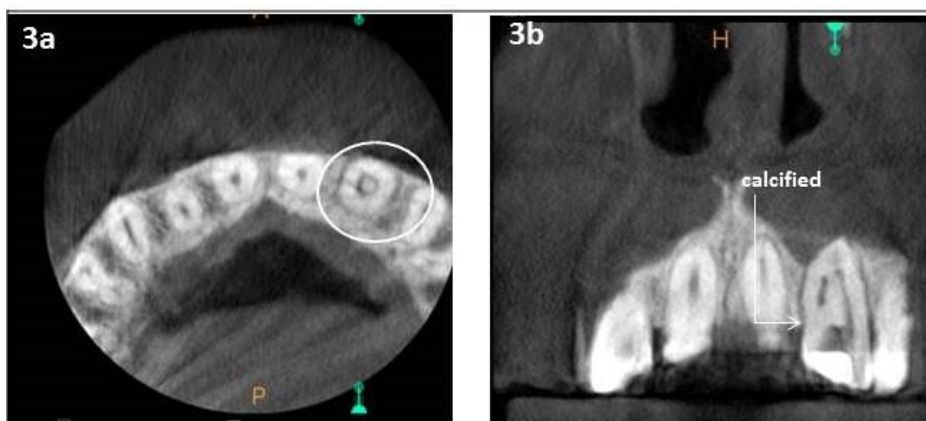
Pre-operative CBCT (axial view), b: sagittal view
